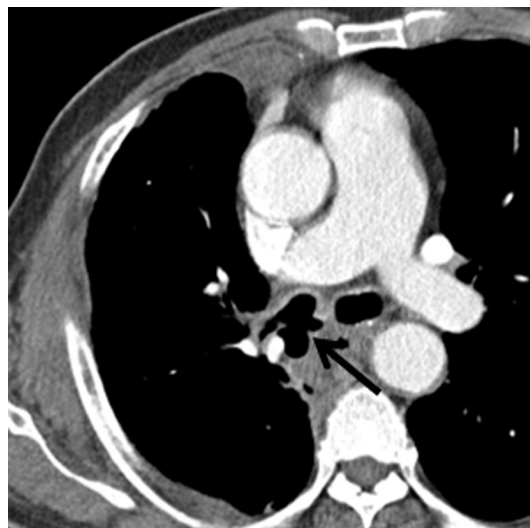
Anastomotic dehiscence of bronchus in a 73-year-old man treated with right middle and lower lobectomy for squamous cell carcinoma. Mediastinal window setting axial CT image shows defective posterior bronchial wall (arrows) in the bronchial stump. Subsequent bronchoscopy demonstrated bronchial dehiscence
